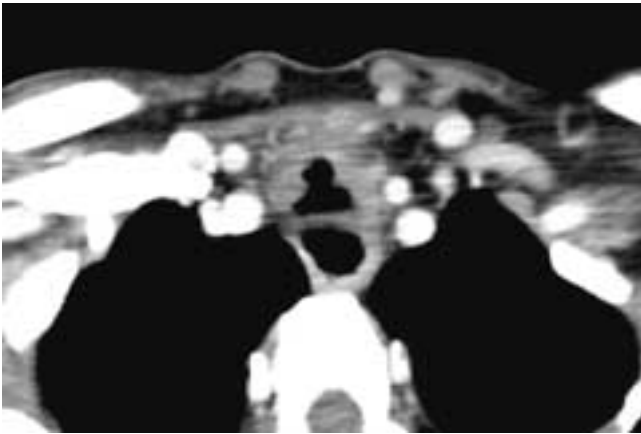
Axial contrast-enhanced CT scan shows a semilunar tracheal stenosis corresponding to the type of injury shown in [Figure 31-18](#). The tracheal cartilages in this patient were poorly calcified.
